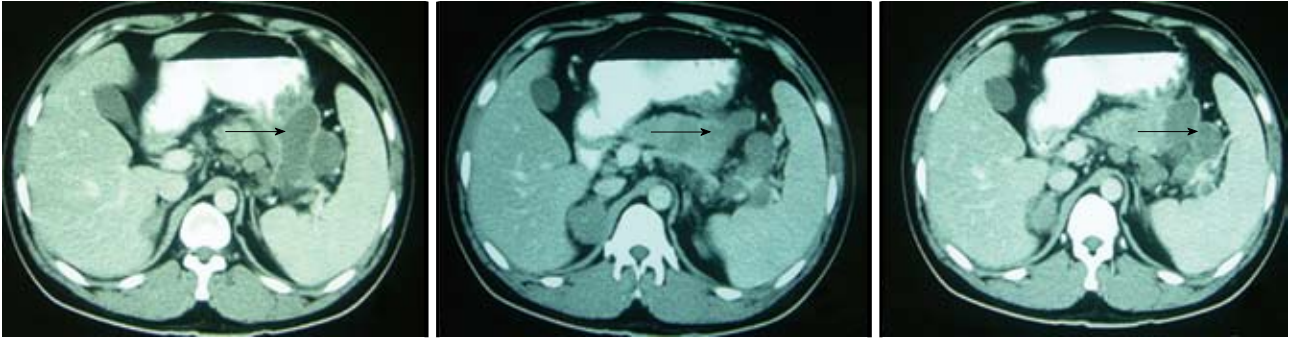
A computed tomography scan revealed a low-density heterogeneous mass of 81 mm × 68 mm in size in the tail of the pancreas (arrow) that invaded the greater curvature of the stomach and the spleen.
